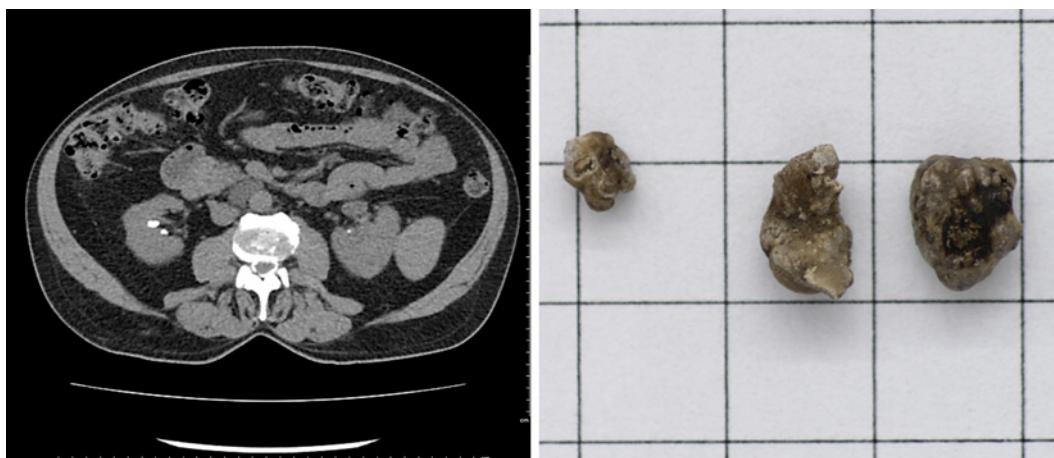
Left panel: Abdominal CT scan. The largest stone in the right kidney had a radiodensity of 636 Hounsfield units. Right panel: Surgically removed kidney stones. Each square is 5 × 5 mm. CT, computed tomography.
